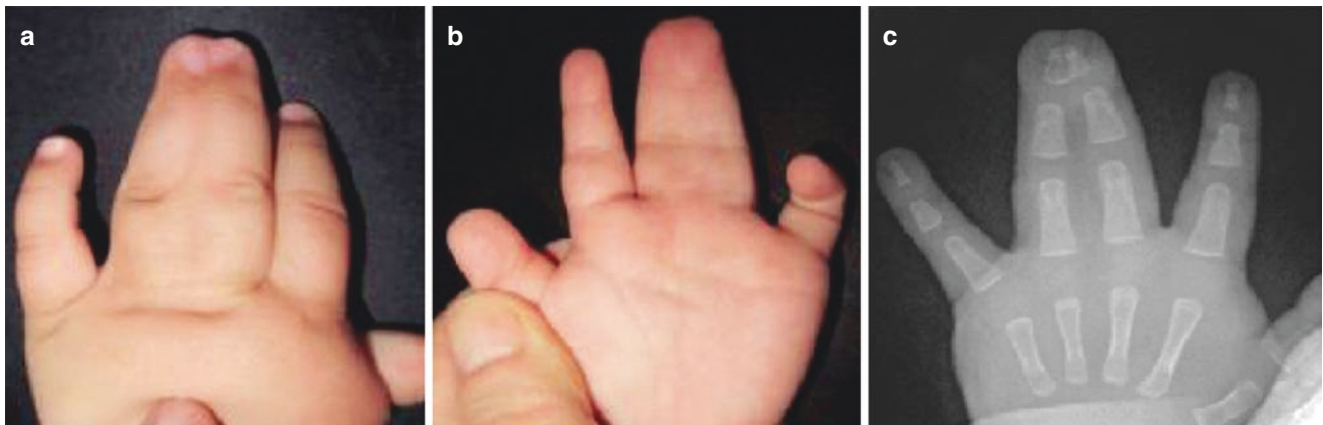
Combined syndactyly: lateral fusion between distal phalanges. (a, b) Hand appearance. (c) X-ray findings
